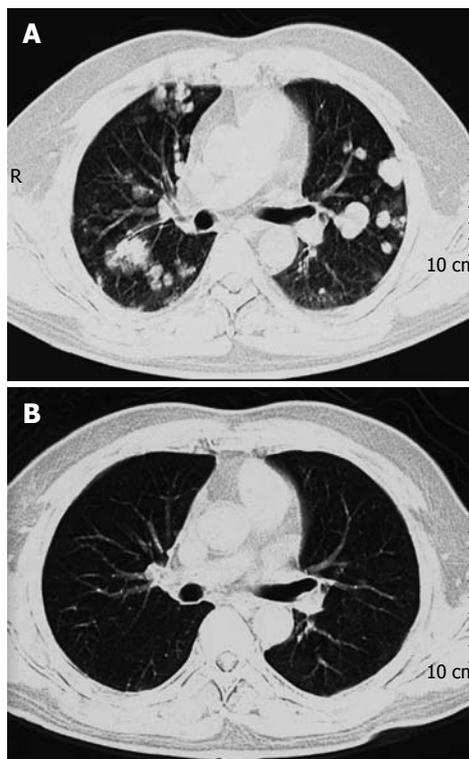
Overall survival. A: Computed tomography (CT) scan showing multiple metastatic nodules in both lung lobes before anti-tumor treatment in a 54-year-old male patient with lung metastasis due to hepatocellular carcinoma; B: CT scan showing the disappearance of previous lung metastatic nodules in 5 mo after γ -knife radiosurgery and oral sorafenib.
